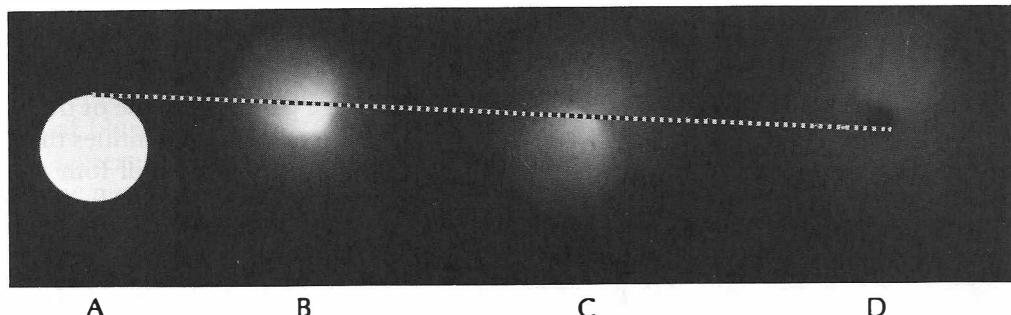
Plain film of a coin (A) and three circular tomograms taken with the coin at different distances from the focal plane (B-D)
